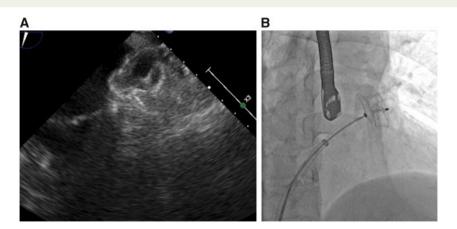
The deployed left atrial appendage closure device (24-mm AmplatzerTM AmuletTM) was confirmed with transoesophageal echocardiographic imaging (A) and fluoroscopic imaging (B).
